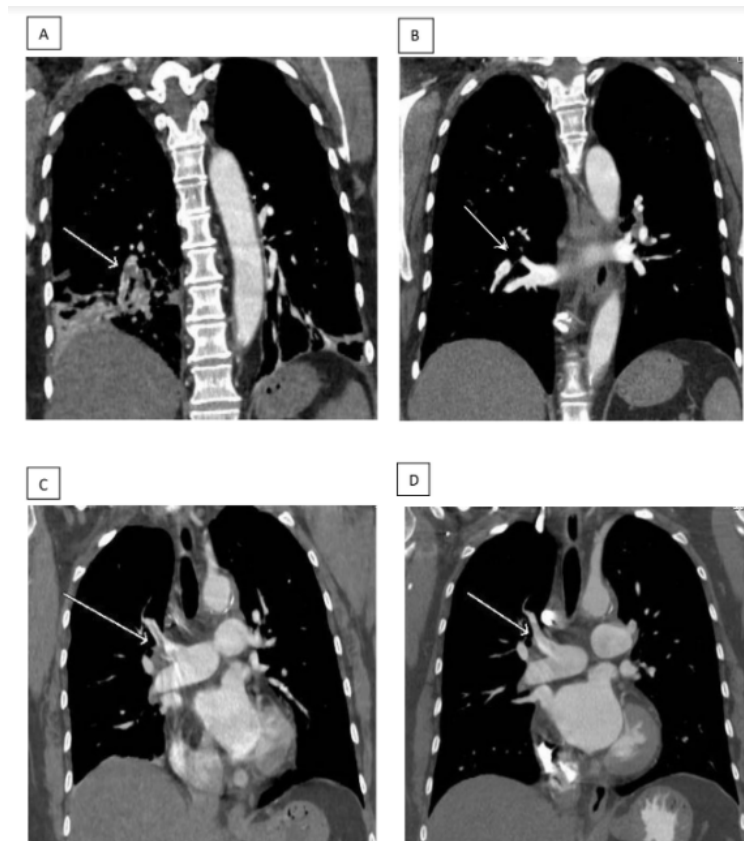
Image A. CT chest with contrast (Coronal view): Arrow shows the presence of Right Lower Lobe PE. Image B. CT chest with contrast (Coronal view): Arrow shows resolution of Right Lower Lobe PE. Image C. CT chest with contrast (Coronal view): Arrow shows the presence of Right Upper Lobe PE. Image D. CT chest with contrast (Coronal view): Arrow shows resolution of Right Upper Lobe PE.
